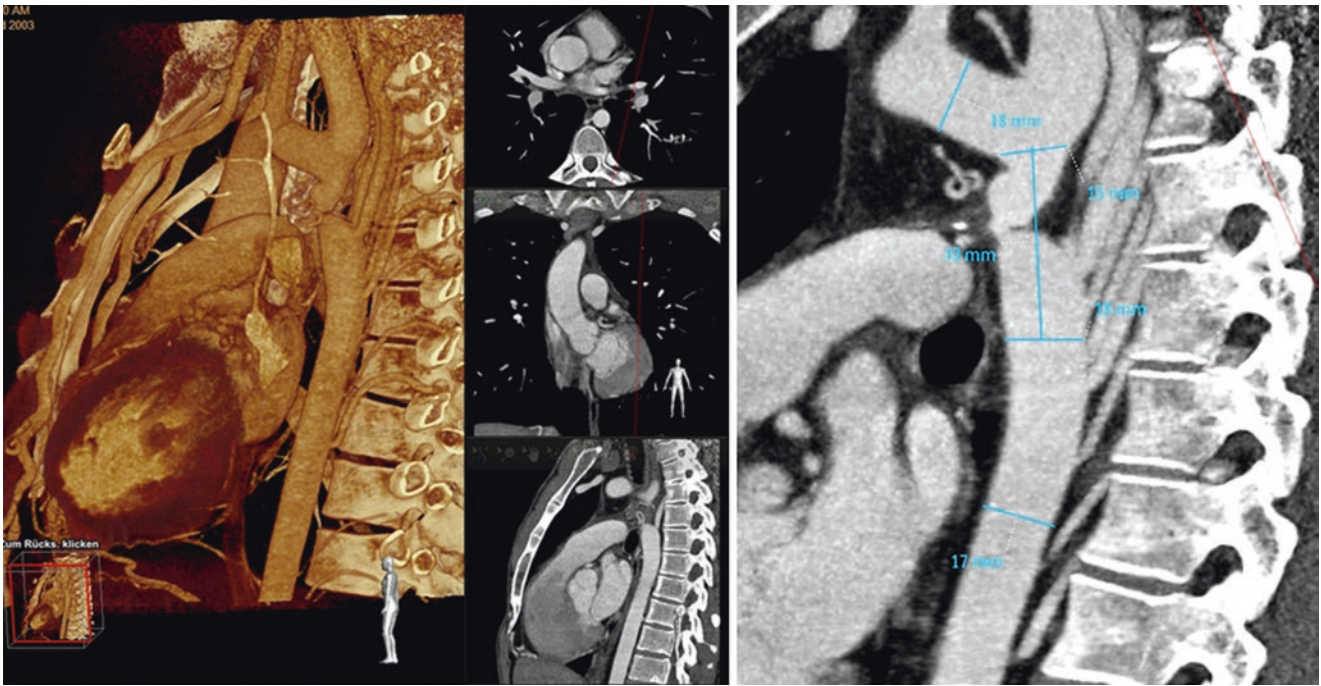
CT data as used for planning of the procedure in this patient with native CoA imported into VesselNavigator (left). Numerous collateral vessels can be seen connecting from dorsally into the descending
